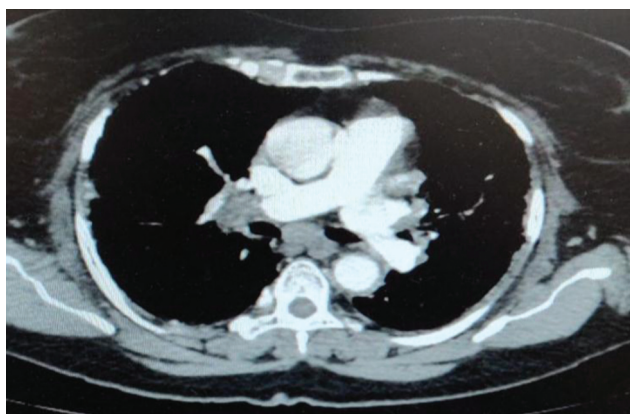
Computed tomographic image of the chest demonstrating hilar and subcarinal lymph nodes.
